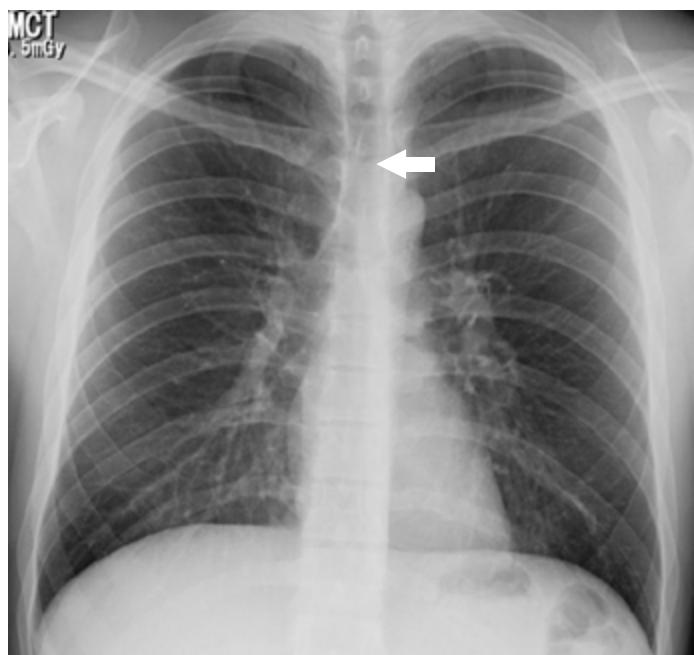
PA chest x-ray: pneumomediastinum, delimitation of anatomical structures allowing a neat visualization of its contours (arrow).
